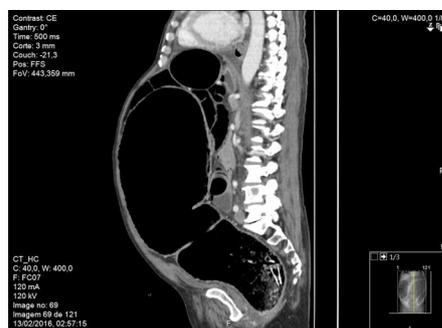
CT scan—sagittal plane—marked colic dilatation with rectum foreign bodies.
